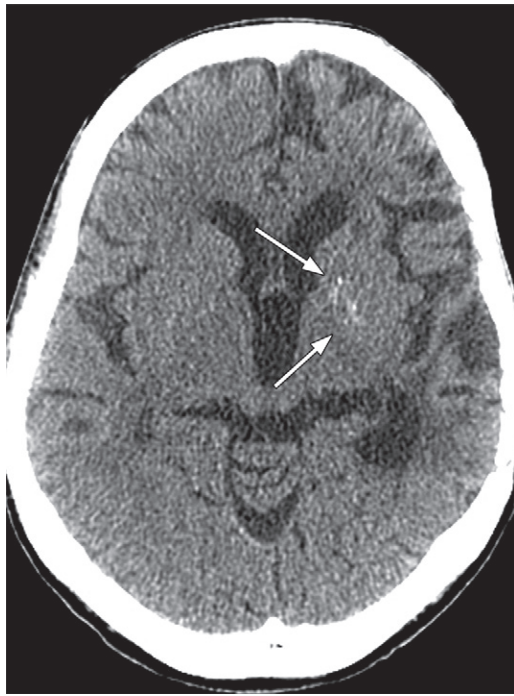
Mineralizing microangiopathy (dystrophic calcification) in a 49-year-old man who underwent focal irradiation (standard-fractionation type) after surgical resection of a left temporal lobe glioma. Axial CT image shows punctate areas of calcifications (arrows) in the left basal ganglia.
